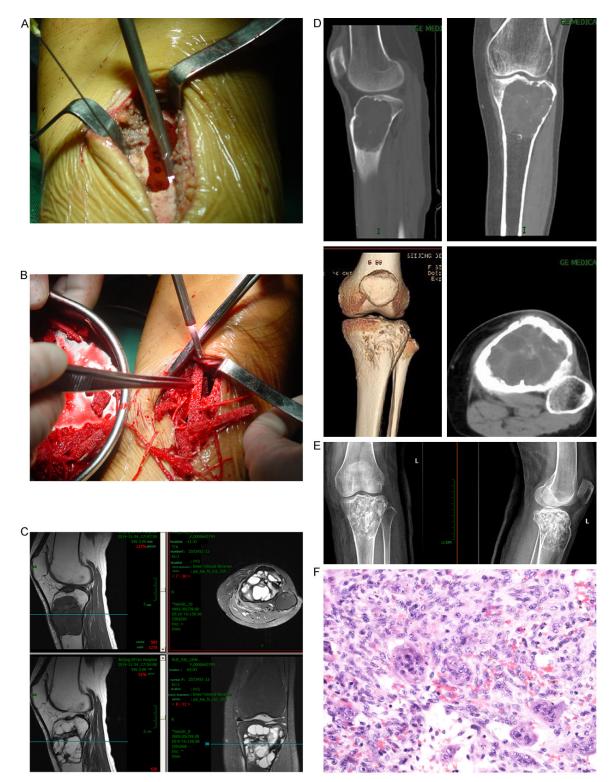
A. Sufficient fenestration as well as repeatedly grind and scratch on the tumor chamber wall was necessary until tumor tissue was completely cleared away in the naked eyesight during operation. We carefully reserved the normal bone and epiphysial bone lamella. B. Filled with allograft and/or homograft bone in during operation. C. November 2012, a 65-year-old female complained of pain left and claudication for 3 months. She diagnosed with left the proximal tibia bone giant cell tumors and HIV infection in the left the proximal tibia bone giant cell tumors. Preoperation MRI imaging findings. D. Radiographs show the preoperation situation: the tumor decenter growth, large erosion extent, multilocular, cortical bone expansion and thinning. E. After 15 months later, tumor resection radiographs (lateral radiograph) show left the proximal tibia bone after ultrasonic scalpel burr curettage, combined with local methotrexate gelfoam adjuvant treatment and filled with allograft and/or homograft bone. No local recurrences. The bone is filled and healed well. Left the proximal tibia has no collapse or fracture at final 15 months follow-up study. F. Pathological examination indicates cystic and necrosis.
